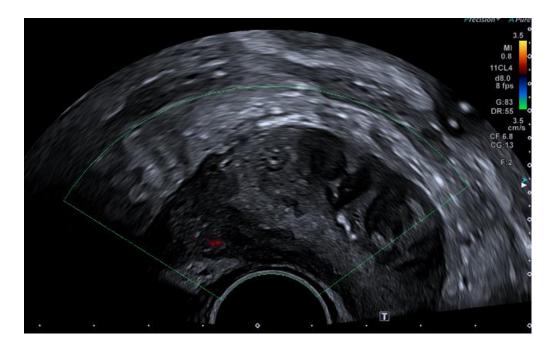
Standard US image of high-risk prostate with ROI in right peripheral zone. Small area of colour Doppler signal identified. TS section
